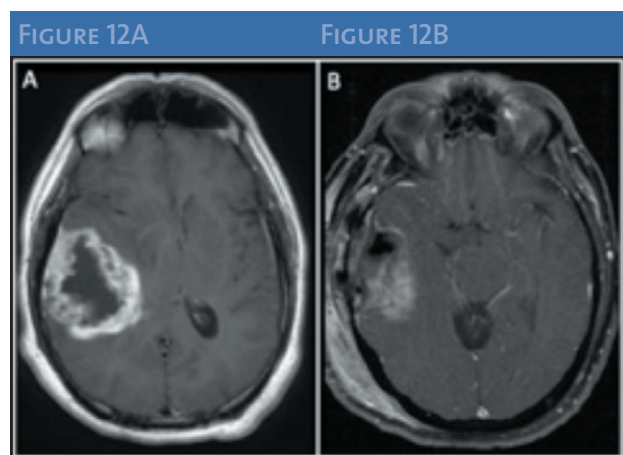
(A) Preoperative axial T1-weighted magnetic resonance imaging with contrast depicting a right temporoparietal lobe mass with imaging characteristics consistent with high-grade glioma. (B) Postoperative axial T1-weighted magnetic resonance imaging showing subtotal resection of tumor with residual in the posterior temporal region. The extent of resection was estimated at >90%.
